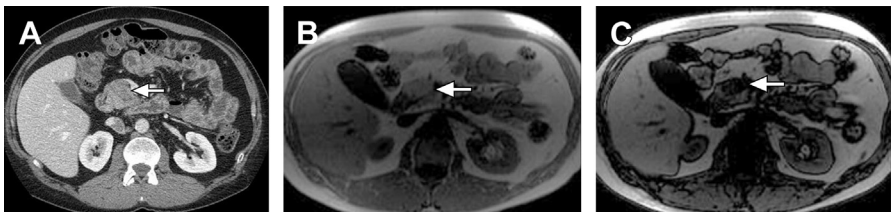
Role of MRI in evaluating suspected lesions in the pancreas. (A) Axial contrast-enhanced multidetector computed tomography (MDCT) image through the pancreatic head demonstrate an ill-defined hypodense masslike area (*arrow*) concerning for pancreatic adenocarcinoma. Lack of secondary findings such as distal parenchymal atrophy and biliary/pancreatic duct dilatation prompted further evaluation with MRI. (B) In-phase and (C) out-of-phase T1-weighted gradient echo images demonstrate loss of signal in the same region on the out of phase images (*arrows*) consistent with a benign area of focal fat replacement.
